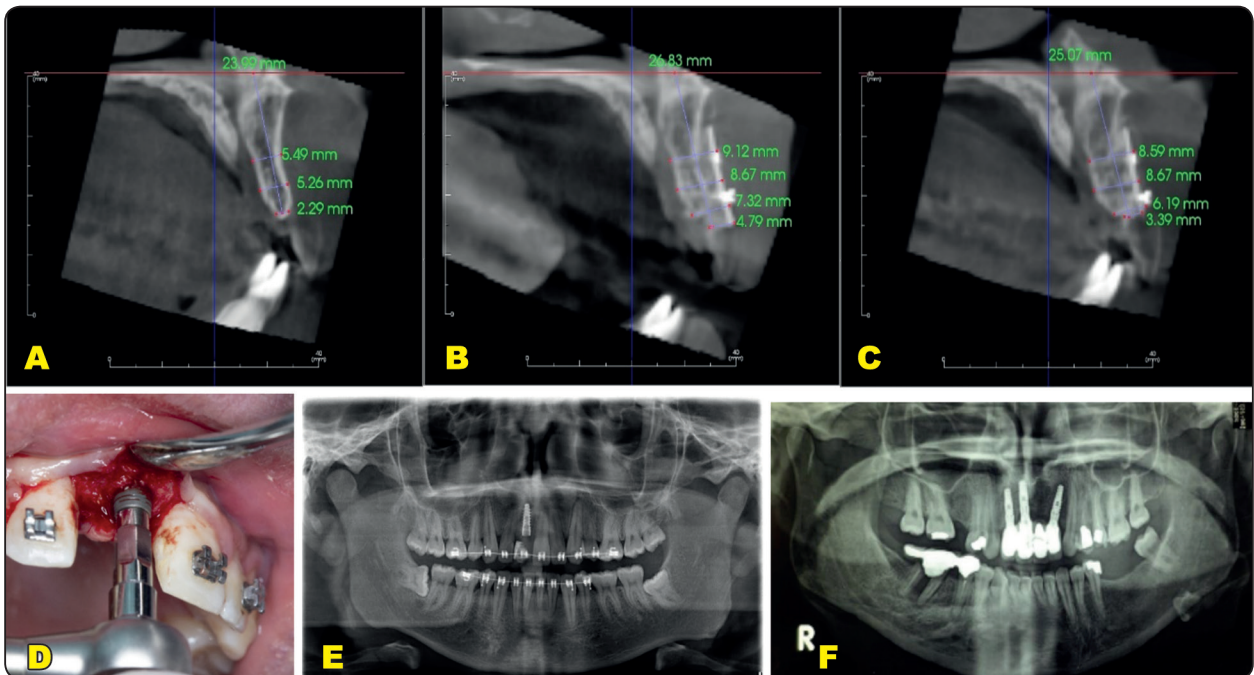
(A-C) CBCT cross-sectional slices (A) Pre-operative; (B) Immediate Post-operative; and (C) 4 months post-operative. (D) Clinical picture of Implant placement in grafted site; (E) Panoramic x-ray following implant placement; (F) Panoramic x-ray following final prosthetics.
